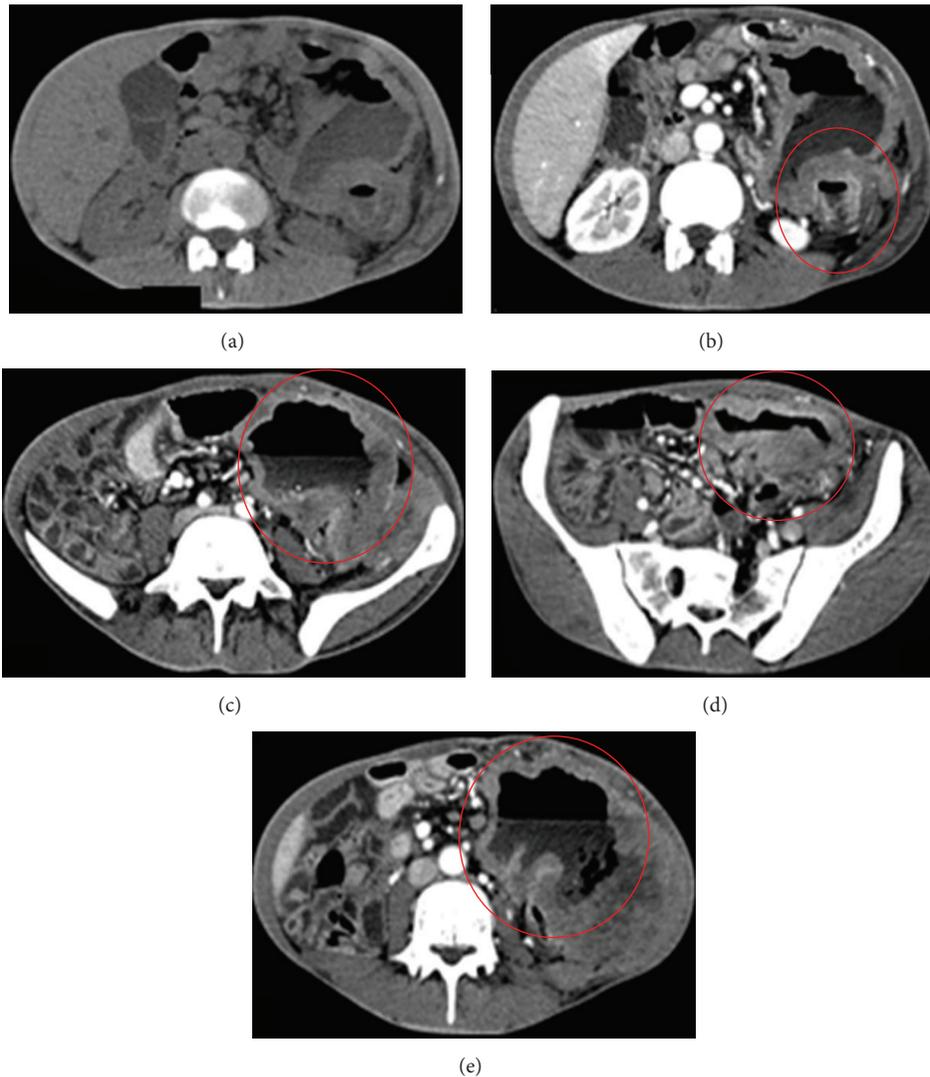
Aneurismatic jejunal lymphoma in a 43-year-old female. (a, b, c) Precontrastographic and postcontrastographic axial CT scan show severe circumferential wall thickening (thickening 17 mm), inhomogeneously hyperdense after contrast medium injection, of a jejunal ileal loop (length: 20 cm) located in the left side and left upper quadrant (red circle). Moreover, endoluminal dilatation and air-fluid level inside and enlarged lymph nodes and the surrounding mesenteric fat can be noticed (arrowheads). (d) Infiltration of the left colonic and sigmoid bowel wall (arrow). (e) Thickened bowel walls are entwined with a newly formed lymphomatous mass of the left abdominal wall that infiltrates the left abdominal wall muscles and the superior edge of the left iliac muscle.
